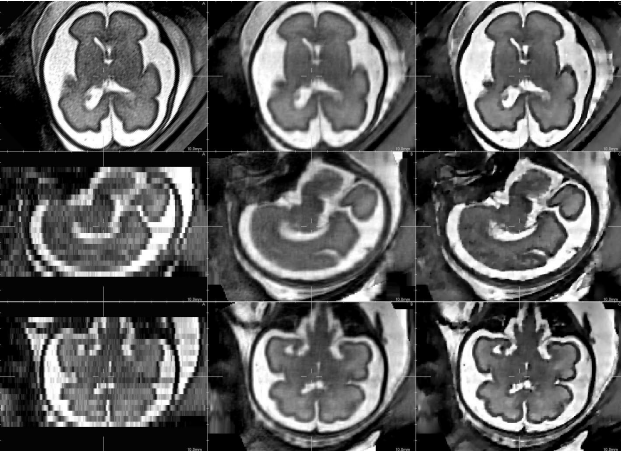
Details of a reconstructed fetal brain T2w MR image using 3 orthogonal LR images. From left to right : A) original low resolution image, B) reconstructed image using local sparse interpolation [2], C) SR reconstruction.
